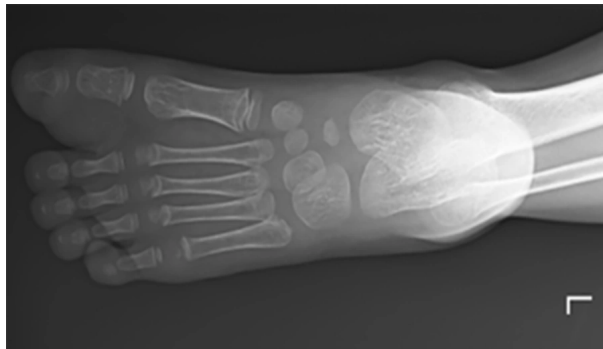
Plain x-ray of the Left foot showing soft tissue mass of the big toe with widening of the first web space
